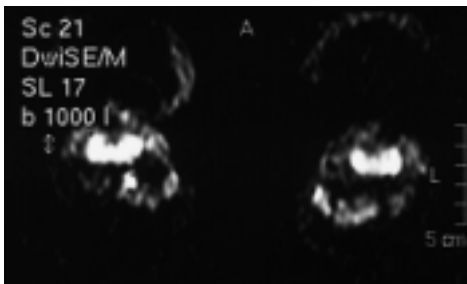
Extension of muscular oedema to ventral muscles in axial diffusion weighted images. This finding was not noticed in conventional MRI.
